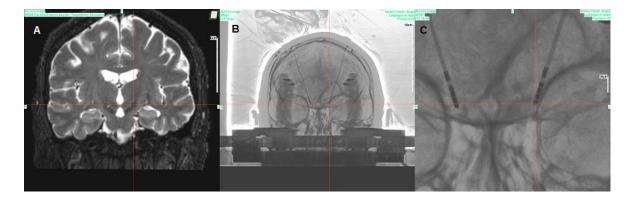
A: Pre-operative MRI image with the red cross visualizing the DBS target (STN); B: intraoperative X-ray for control of electrode position; C: intraoperative X-ray showing two DBS electrodes with four contacts each, the rostral contacts are located in the STN, the furthest caudal contact allows stimulation of the SNr.
